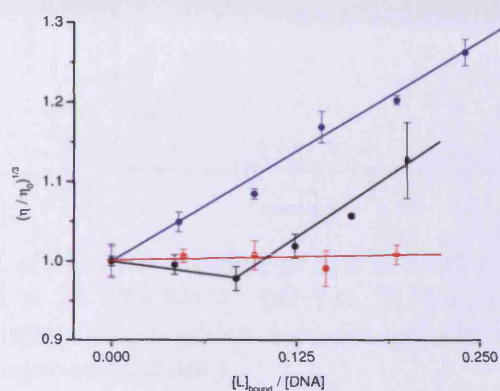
Relative viscosity of a 0.5 mM CT DNA solution upon addition of 5.5 (●), H33258 (●) and ethidium bromide (●) in 25 mM MOPS pH 7.0, 50 mM NaCl, 1 mM EDTA, at 25 °C
